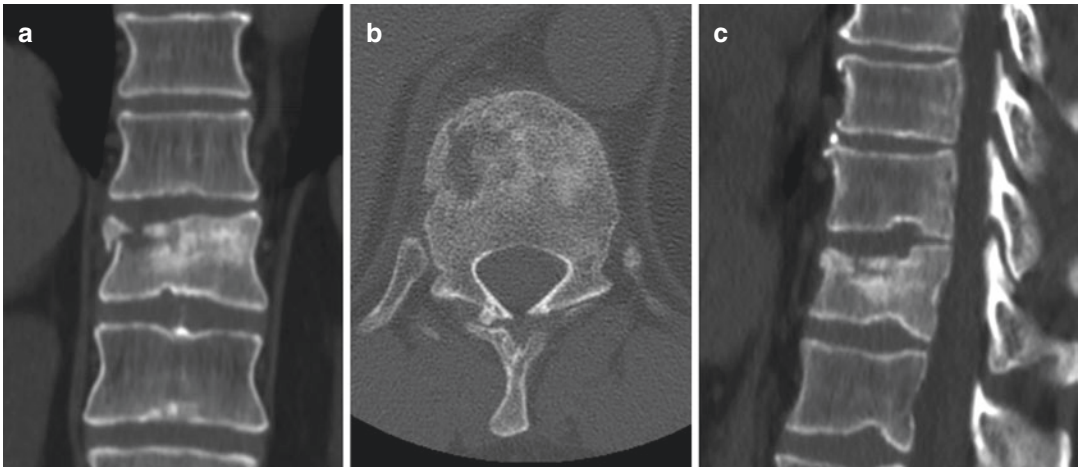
CT of the thoracic spine showing a complete fracture of the upper plate of the soma of D11 with deployment of a fragment of the right antero-lateral portion; coronal (a), axial (b) and sagittal (c) planes
